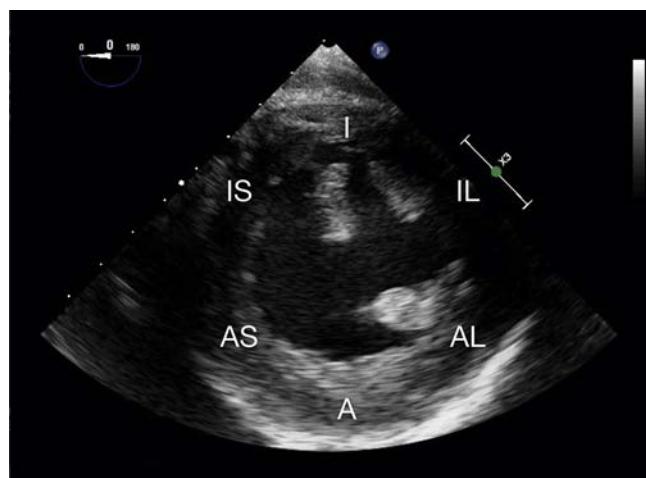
The transesophageal transgastric mid-papillary short axis view (TG SAX) is a common view for qualitative evaluation of global left ventricular systolic function. Basal and apical segments are not visualized in this view, so midesophageal or TG LAX views should also be obtained to provide a more complete picture of the overall function. The TG SAX view includes myocardial segments supplied by each of the coronary arteries, making it useful for detection of new ischemia. The TG SAX view displays the mid inferior (*I*), mid inferolateral (*IL*), mid anterolateral (*AL*), mid anterior (*A*), mid anteroapical (*AS*), and mid inferoseptal (*IS*) segments.
